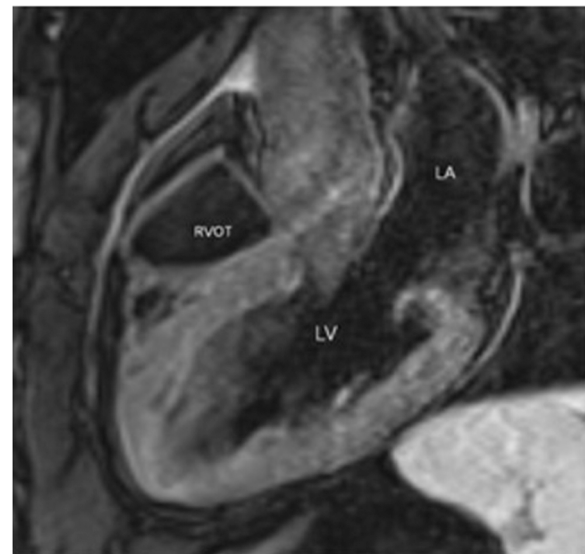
Three-chamber T2-weighted image of left ventricle (LV) and right ventricular outflow tract (RVOT) with T2-weighted TSE sequences: There was no significantly increased signal intensity in the T2-weighted images to suggest edema of active inflammation. The T2-weighted images made before contrast showed mildly increased signal in the septal and lateral free wall of the LV on 3-chamber view and in the mid to anteroapical LV wall in the 2-chamber view.
